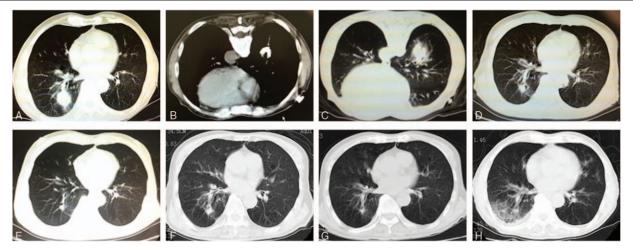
CT images of our patient. (A) The mass in the right lower lobe (October 9, 2014). (B) The effects of RFA (November 11, 2014). (C) The pneumothorax after RFA (November 11, 2014). Follow-up CT showing a PR to RFA on (D) January 14, 2015; (E) March 17, 2015; (F) October 14, 2015; and (G) June 27, 2016. (H) Chest CT shows pneumonia and a PR (January 13, 2017).
